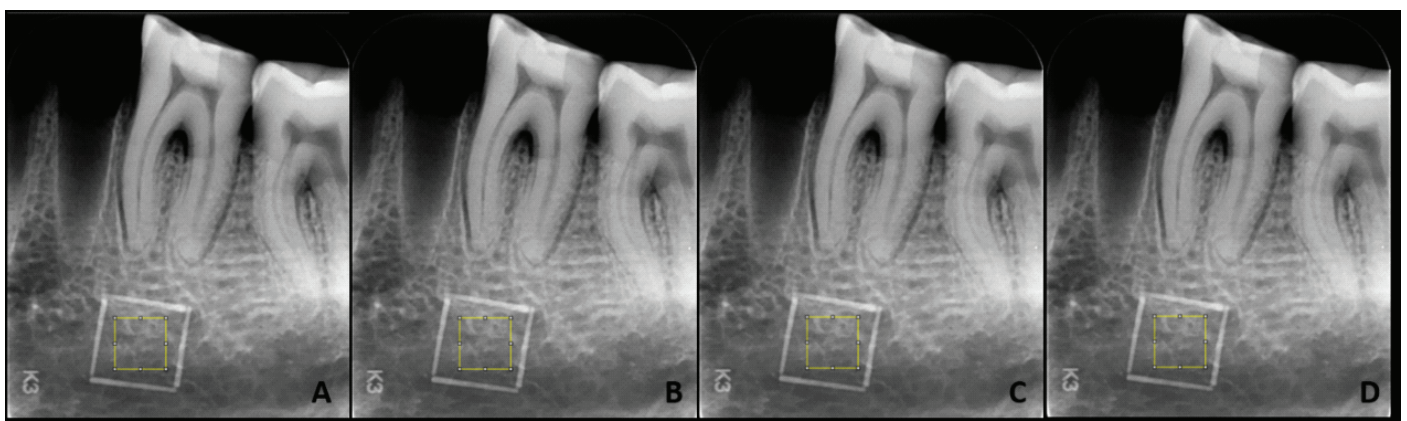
Periapical radiographs with different image formats placed on the marked area. A; DICOM, B; JPEG, C; PNG, D; TIFF.
